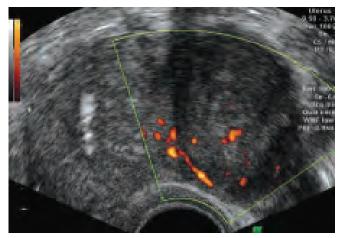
The two-dimensional color Doppler of the uterine artery branches supplying the subserosal fibroid
